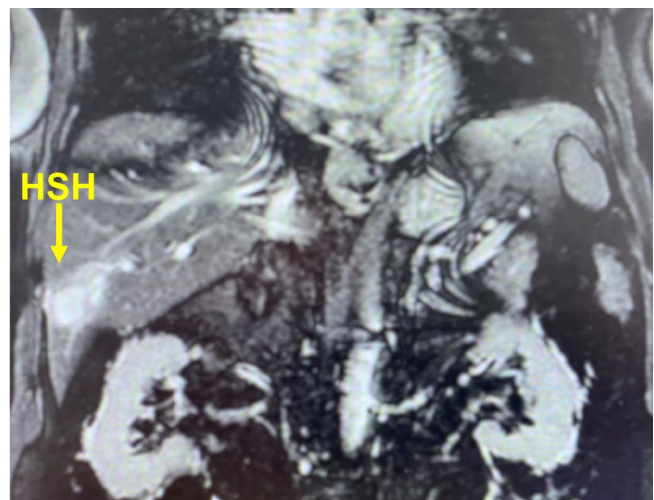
Image of the patient's lesion by MRI. A localized lesion is observed in segment VI, measuring 4 x 4 x 4 cm. Contrast enhancement reveals wall enhancement, with high signal intensity on T2-weighted images.
